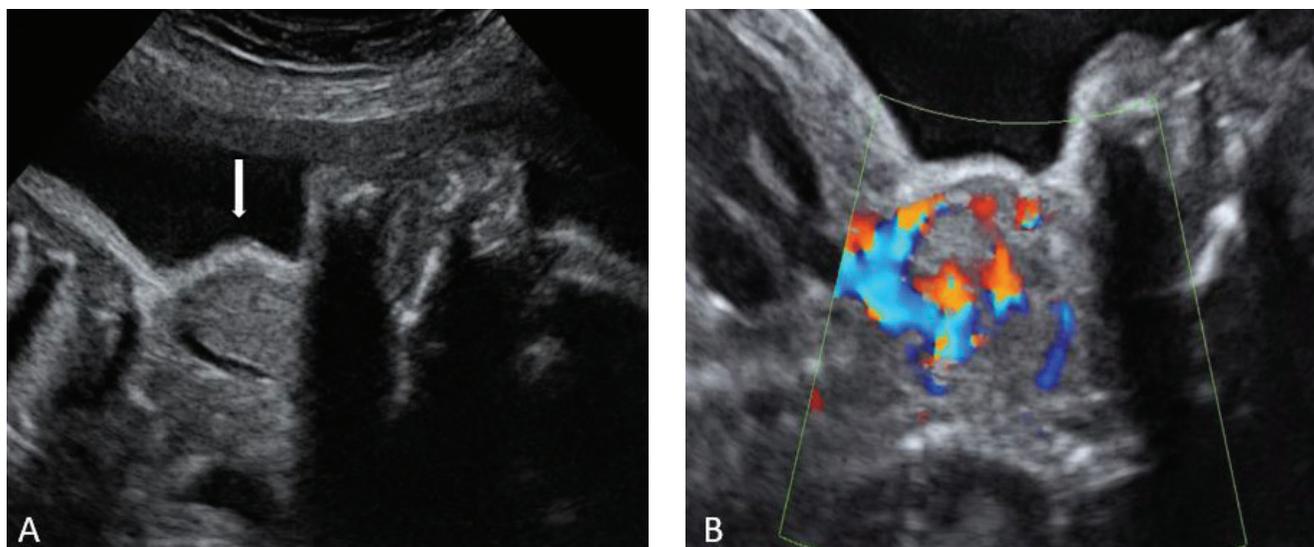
A. Fetal goitre (arrow) in a mother with Graves' disease. B. Diffuse hypervascularity on fetal doppler examination of the same case.
